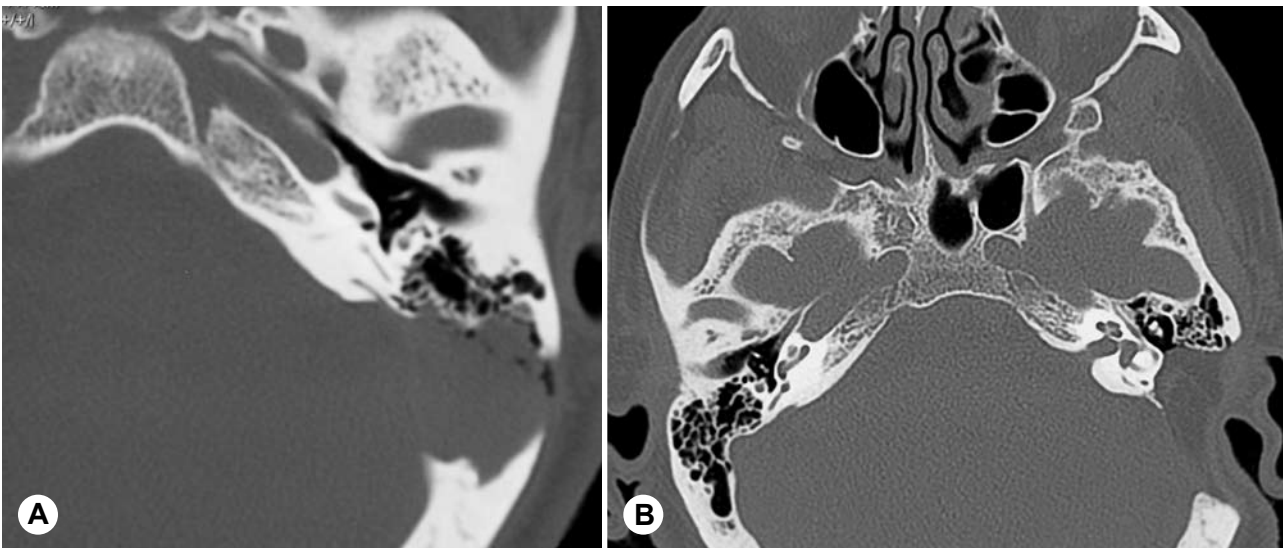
(Patient 3) Axial CT scans. A) Preoperative scan shows cholesteatoma confined to mastoid region. Posterior fossa dura, sigmoid sinus, and endolymphatic sac have been exposed by lesion. B) Postoperative scan shows fat obliteration of mastoid cavity.
